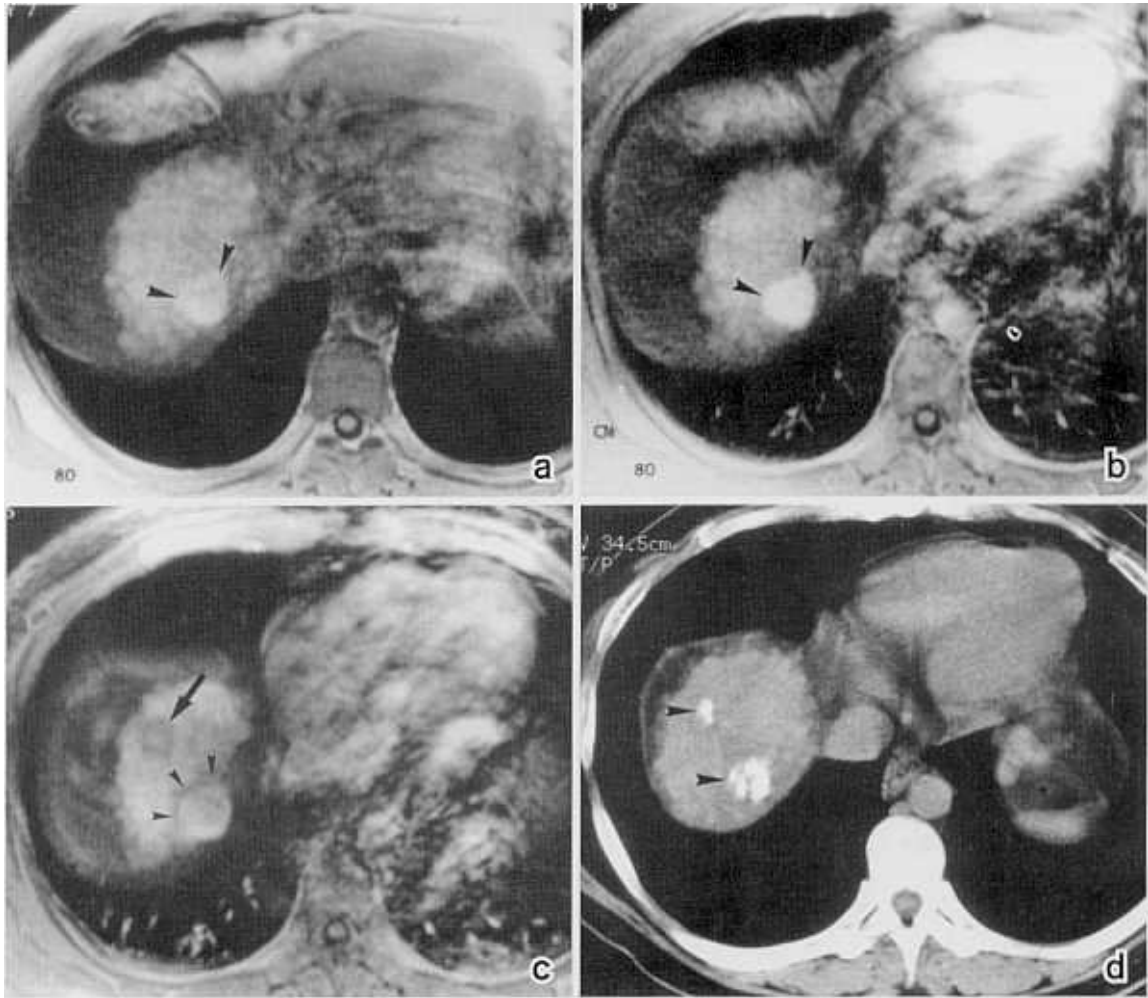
Multiple hepatocellular carcinomas in a 48-year-old man with liver cirrhosis. (a) Unenhanced T1-weighted MR image shows a high signal intensity nodule (arrowheads) in right lobe of liver. (b) Contrast-enhanced MR image obtained during first phase (arterial dominant phase), 10 sec after intravenous administration of contrast agent was started, shows a dense contrast enhancement of right lobe lesion. (c) MR arterial portogram obtained during second phase of imaging 55 sec after initiation of contrast material injection via superior mesenteric artery shows a nodular perfusion defect (arrow) which was not shown during the other static or intravenous dynamic MR imaging. The contrast-enhanced nodule on (b) is distinguished by a low signal intensity rim (arrowheads) which was suggested as compressed hepatic parenchyma from an expansile growth of hepatocellular carcinoma. (d) Iodized oil CT image obtained 21 days after transarterial chemoembolization demonstrates two dense nodular uptakes of iodized oil in the corresponding locations on (c).
